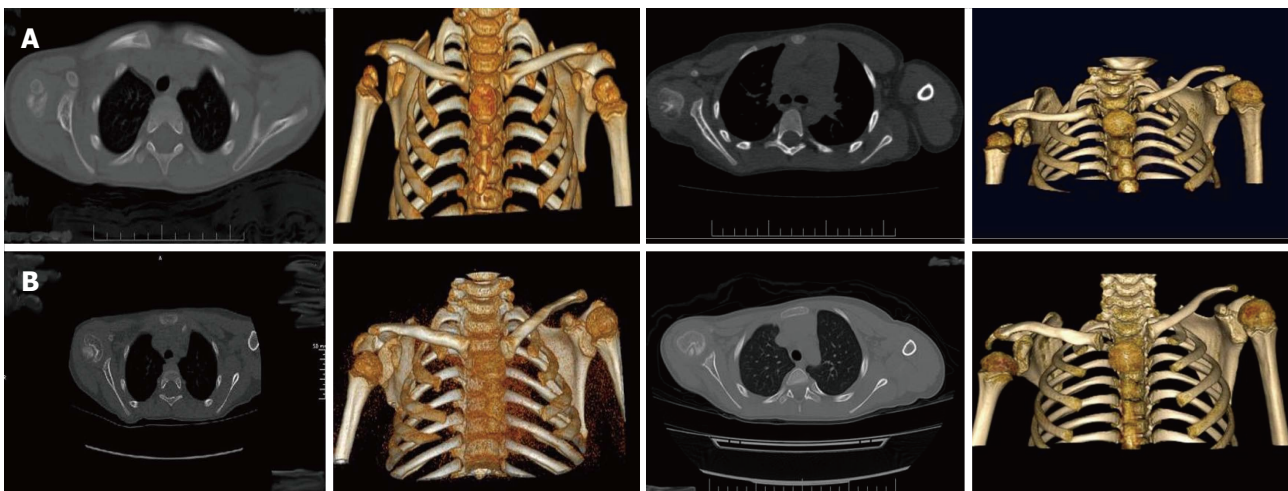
Comparison of computed tomography images of obstetric brachial plexus palsy children, who had surgeries at other clinics before presenting to us (A) and the computed tomography images of the same children at least one-year after having triangle tilt as revision surgery at our clinic (B).
